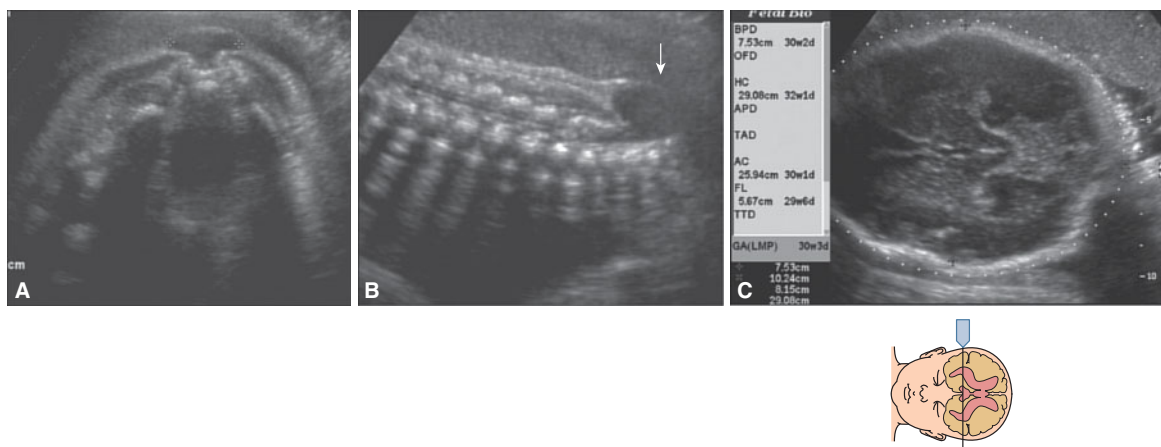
Transabdominal sonography shows a sacral defect of a fetus at 30 postmenstrual weeks. (A) Transverse sections through the spinal defect. Note that the defect is covered by a thin membrane; no skin is covering the defect. In addition, the vertebra has a U-shape. (B) Sagittal section showing the extent of the spinal lesion (arrow). (C) The cerebellum is not seen, as it has completely herniated.
